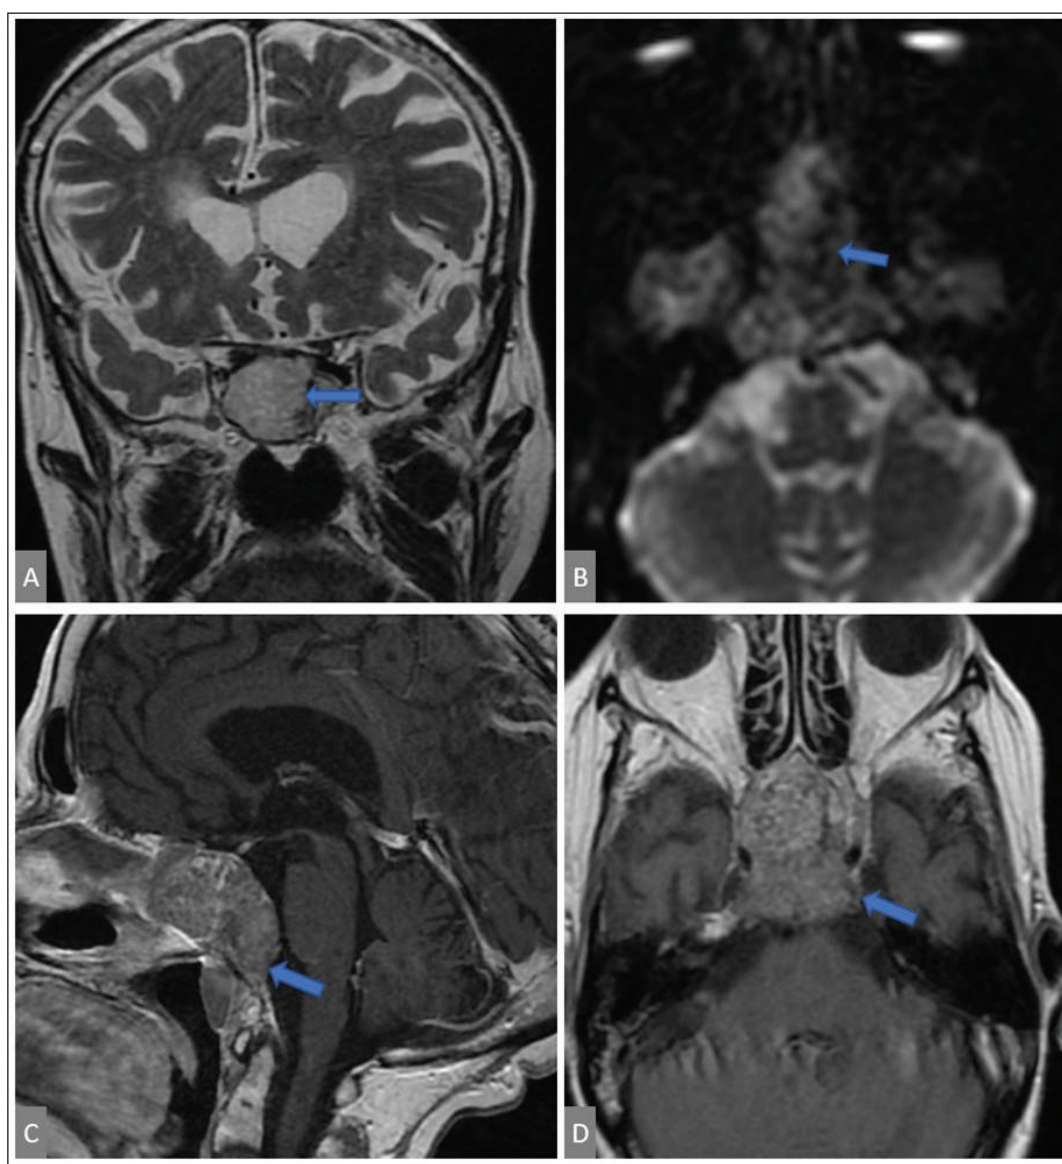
A 65-year-old man presenting with a 2-week history of progressive bilateral ophthalmoplegia, visual disturbances, and headache. Coronal T2-weighted MRI (1.5 T) (a) demonstrates a lobulated clival and sphenoid body mass with heterogeneous signal, including areas of T2 hyperintensity reflecting the myxoid matrix of chordoma. Axial diffusion-weighted imaging (b) shows no significant diffusion restriction. Sagittal (c) and axial (d) post-gadolinium T1-weighted images reveal moderate heterogeneous enhancement with aggressive local extension involving both cavernous sinuses, the pituitary gland, the sphenoid sinus, and the right orbital apex, consistent with clival chordoma. All images are fully anonymized and reproduced with written patient consent.
